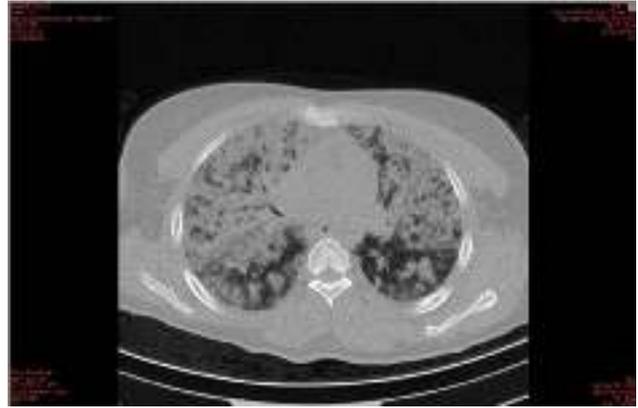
Diffuse alveolar hemorrhage in thorax CT in parenchyma view
